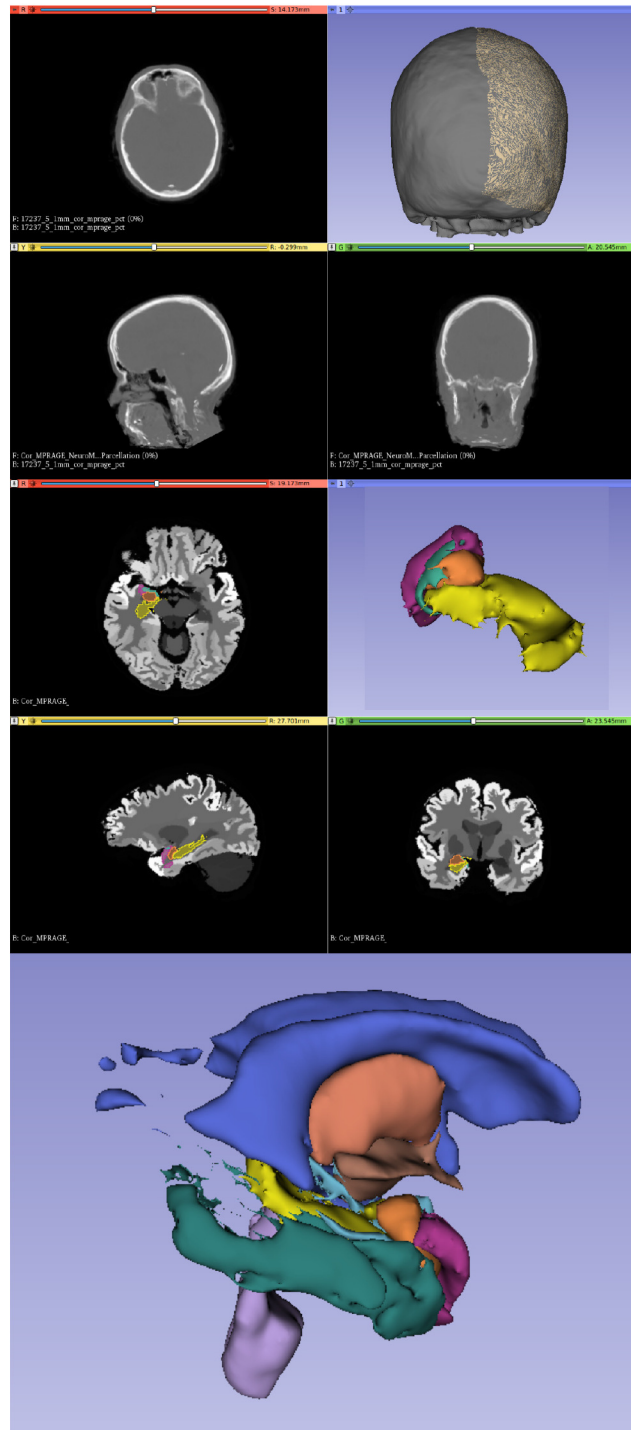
(Top) The pseudo-CT is segmented through thresholding and the skull surface mesh of the selected hemisphere is considered. (Middle) The ablation target regions are extracted from the patient's MRI parcellation: hippocampus (yellow), amygdala (orange), temporal piriform cortex (light green) and entorhinal cortex (purple). (Bottom) Sensitive brain structures surrounding the ablation area are also extracted from the parcellation: ventricles (blue), brain-stem (violet), thalamus (salmon) and the PHG (light blue) on the back with respect to the FuG (dark green).
